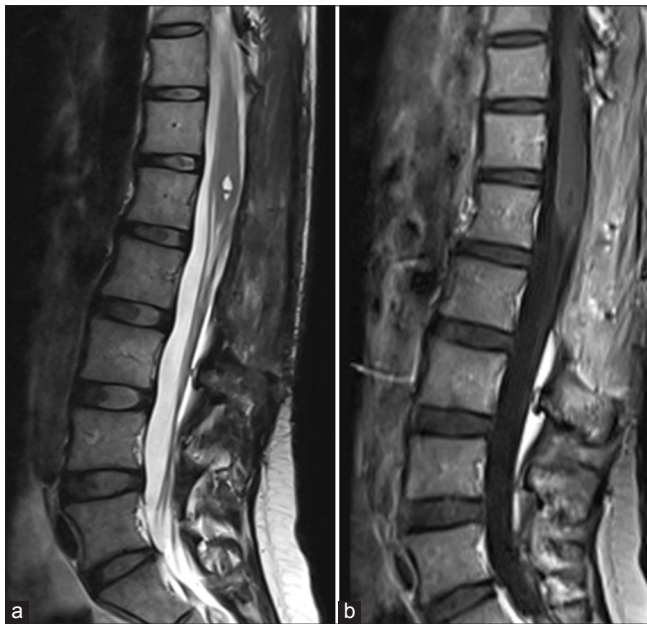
Postoperative magnetic resonance imaging (MRI) performed at 3 months after surgery demonstrating complete resection of both cauda equina and conus medullaris lesions. (a and b) Left image shows a sagittal T2 conus medullaris hypersignal without any signs of residual disease (no contrast enhancement) on T1 gadolinium imaging. MRI showed no signs of recurrent cauda equina myxopapillary ependymoma.
